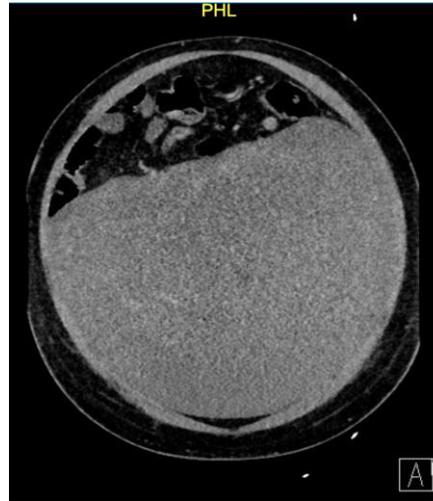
CT imaging (coronal) demonstrating the well-circumscribed mass measuring 33.9 cm x 22.8 cm x 20.4 cm.
